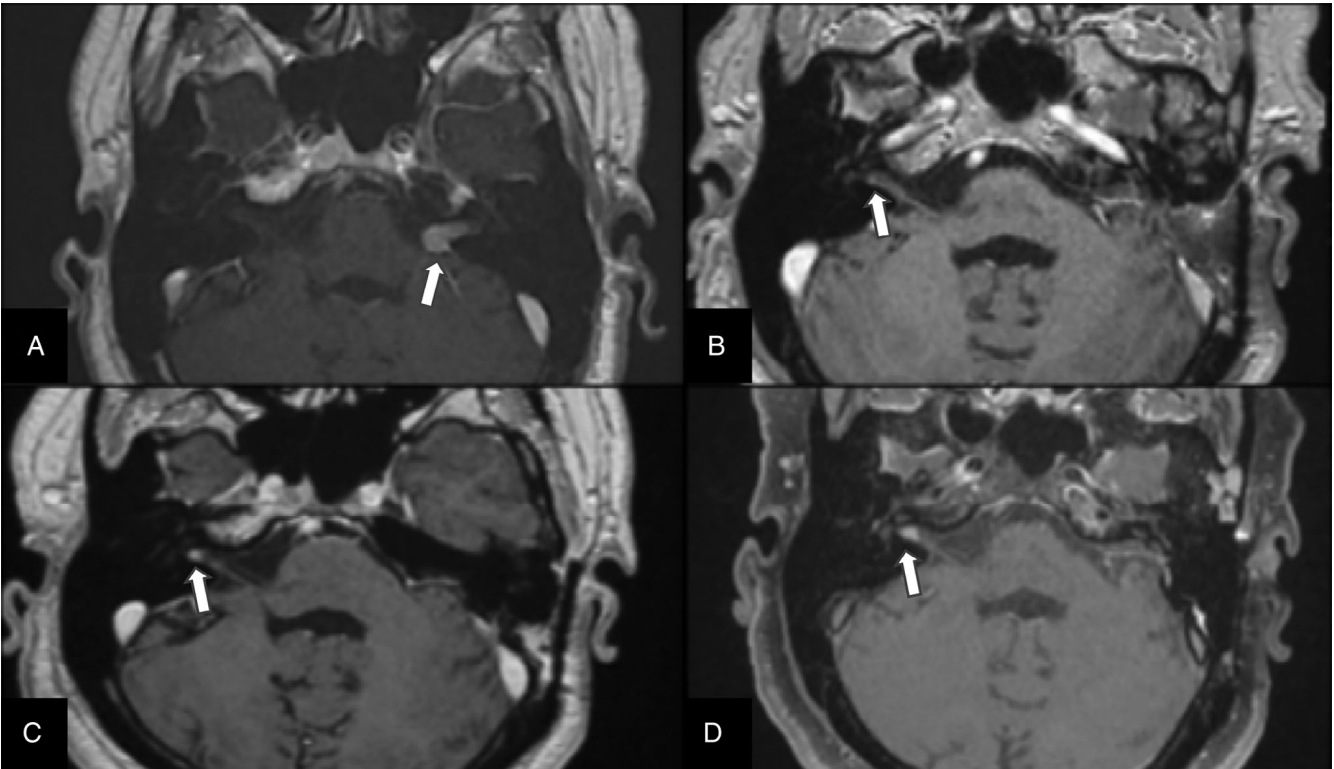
Case 3. (A) Preoperative axial T1-weighted gadolinium-enhanced magnetic resonance imaging (MRI) showing left-side vestibular schwannoma (VS) (white arrow). (B–D) Postoperative axial T1-weighted gadolinium-enhanced MRI scans showing the initial growth (B, C) and secondary stabilization (C, D) of the contralateral right side VS in (whites arrows).
